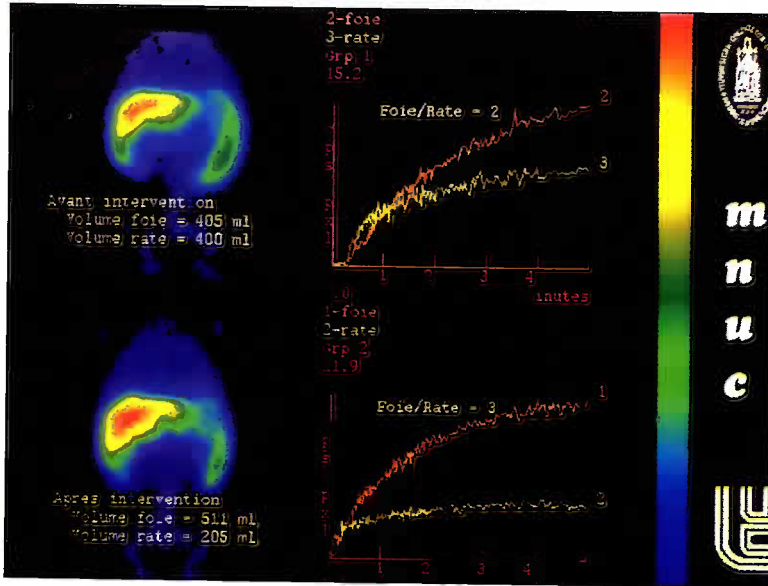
Hepatic scintigraphy (99 mTC sulfur colloidal) performed 2 days before and 1 week after mesenterico-Rex bypass for extrahepatic portal hypertension. It showed an increase in hepatic volume and in the hepatic/splenic blood flow ratio, as well as a decrease in the volume of the spleen.
